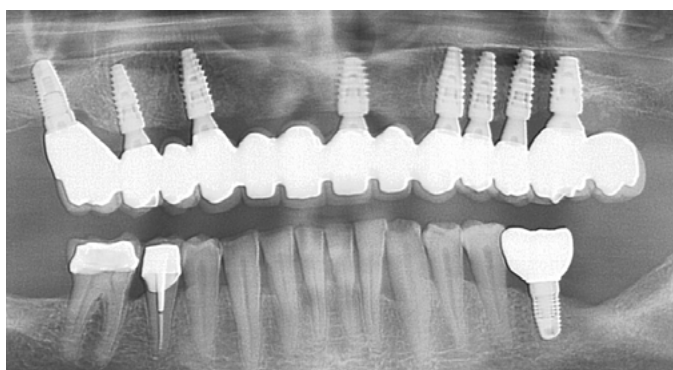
5-year post-op panoramic x-ray
